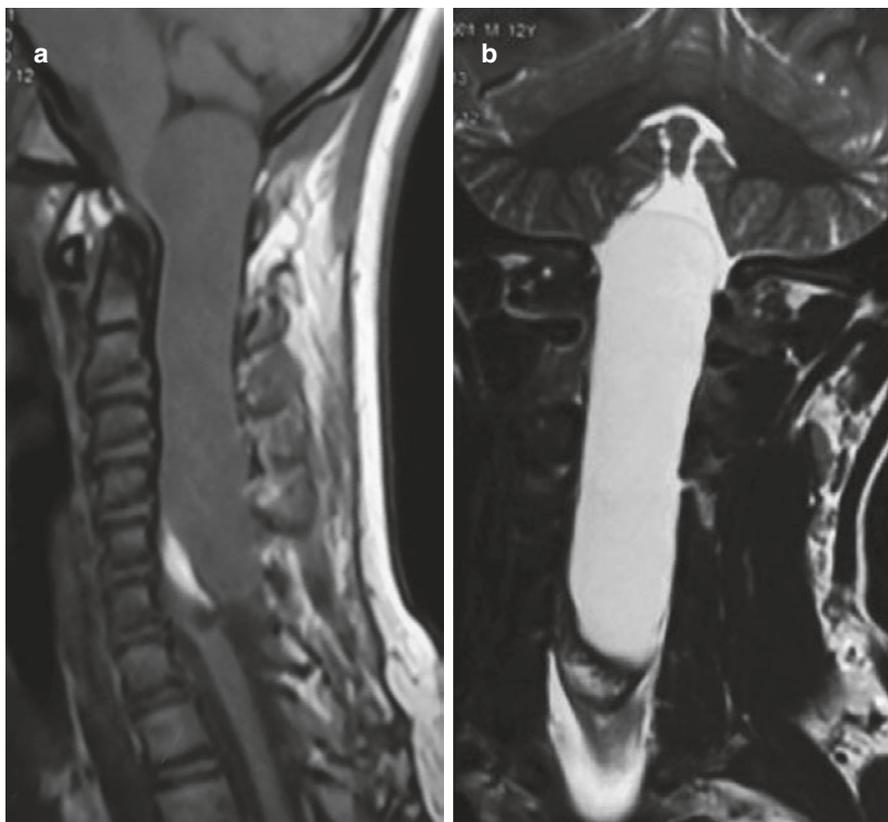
(a) T1 sagittal and (b) T2 coronal MR images showing a long segment neurenteric cyst extending from the cervicomedullary junction to the cervicothoracic junction posterior to the cord with an abnormally shaped vertebral body and an anteroinferiorly placed fibrolipoma, causing adhesion to the spinal cord. (From Shukla et al. [14]; with permission)
